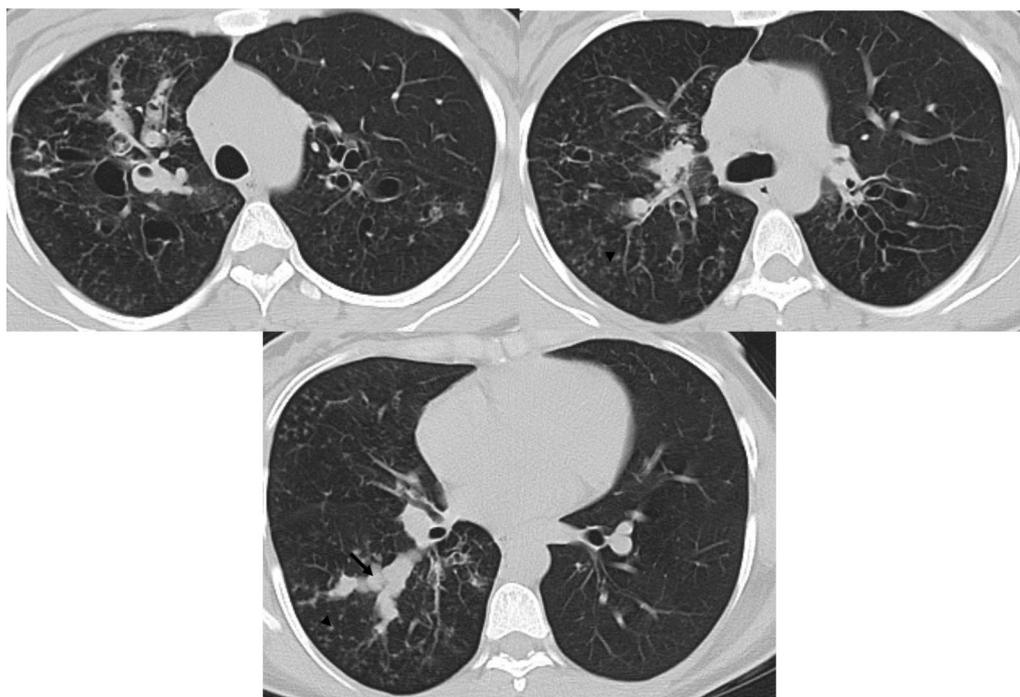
A 39-year-old male complaining of fever, night sweats, productive cough with occasional blood streaking in the sputum and weight loss for about 6 months. HRCT of the chest in a, b axial lung window images showing bilateral multiple well-defined centri-lobular and tree-in-bud nodules with bronchiectatic changes and upper lobar cavitation. The diagnosis of active granulomatous infection (pulmonary tuberculosis) was made
